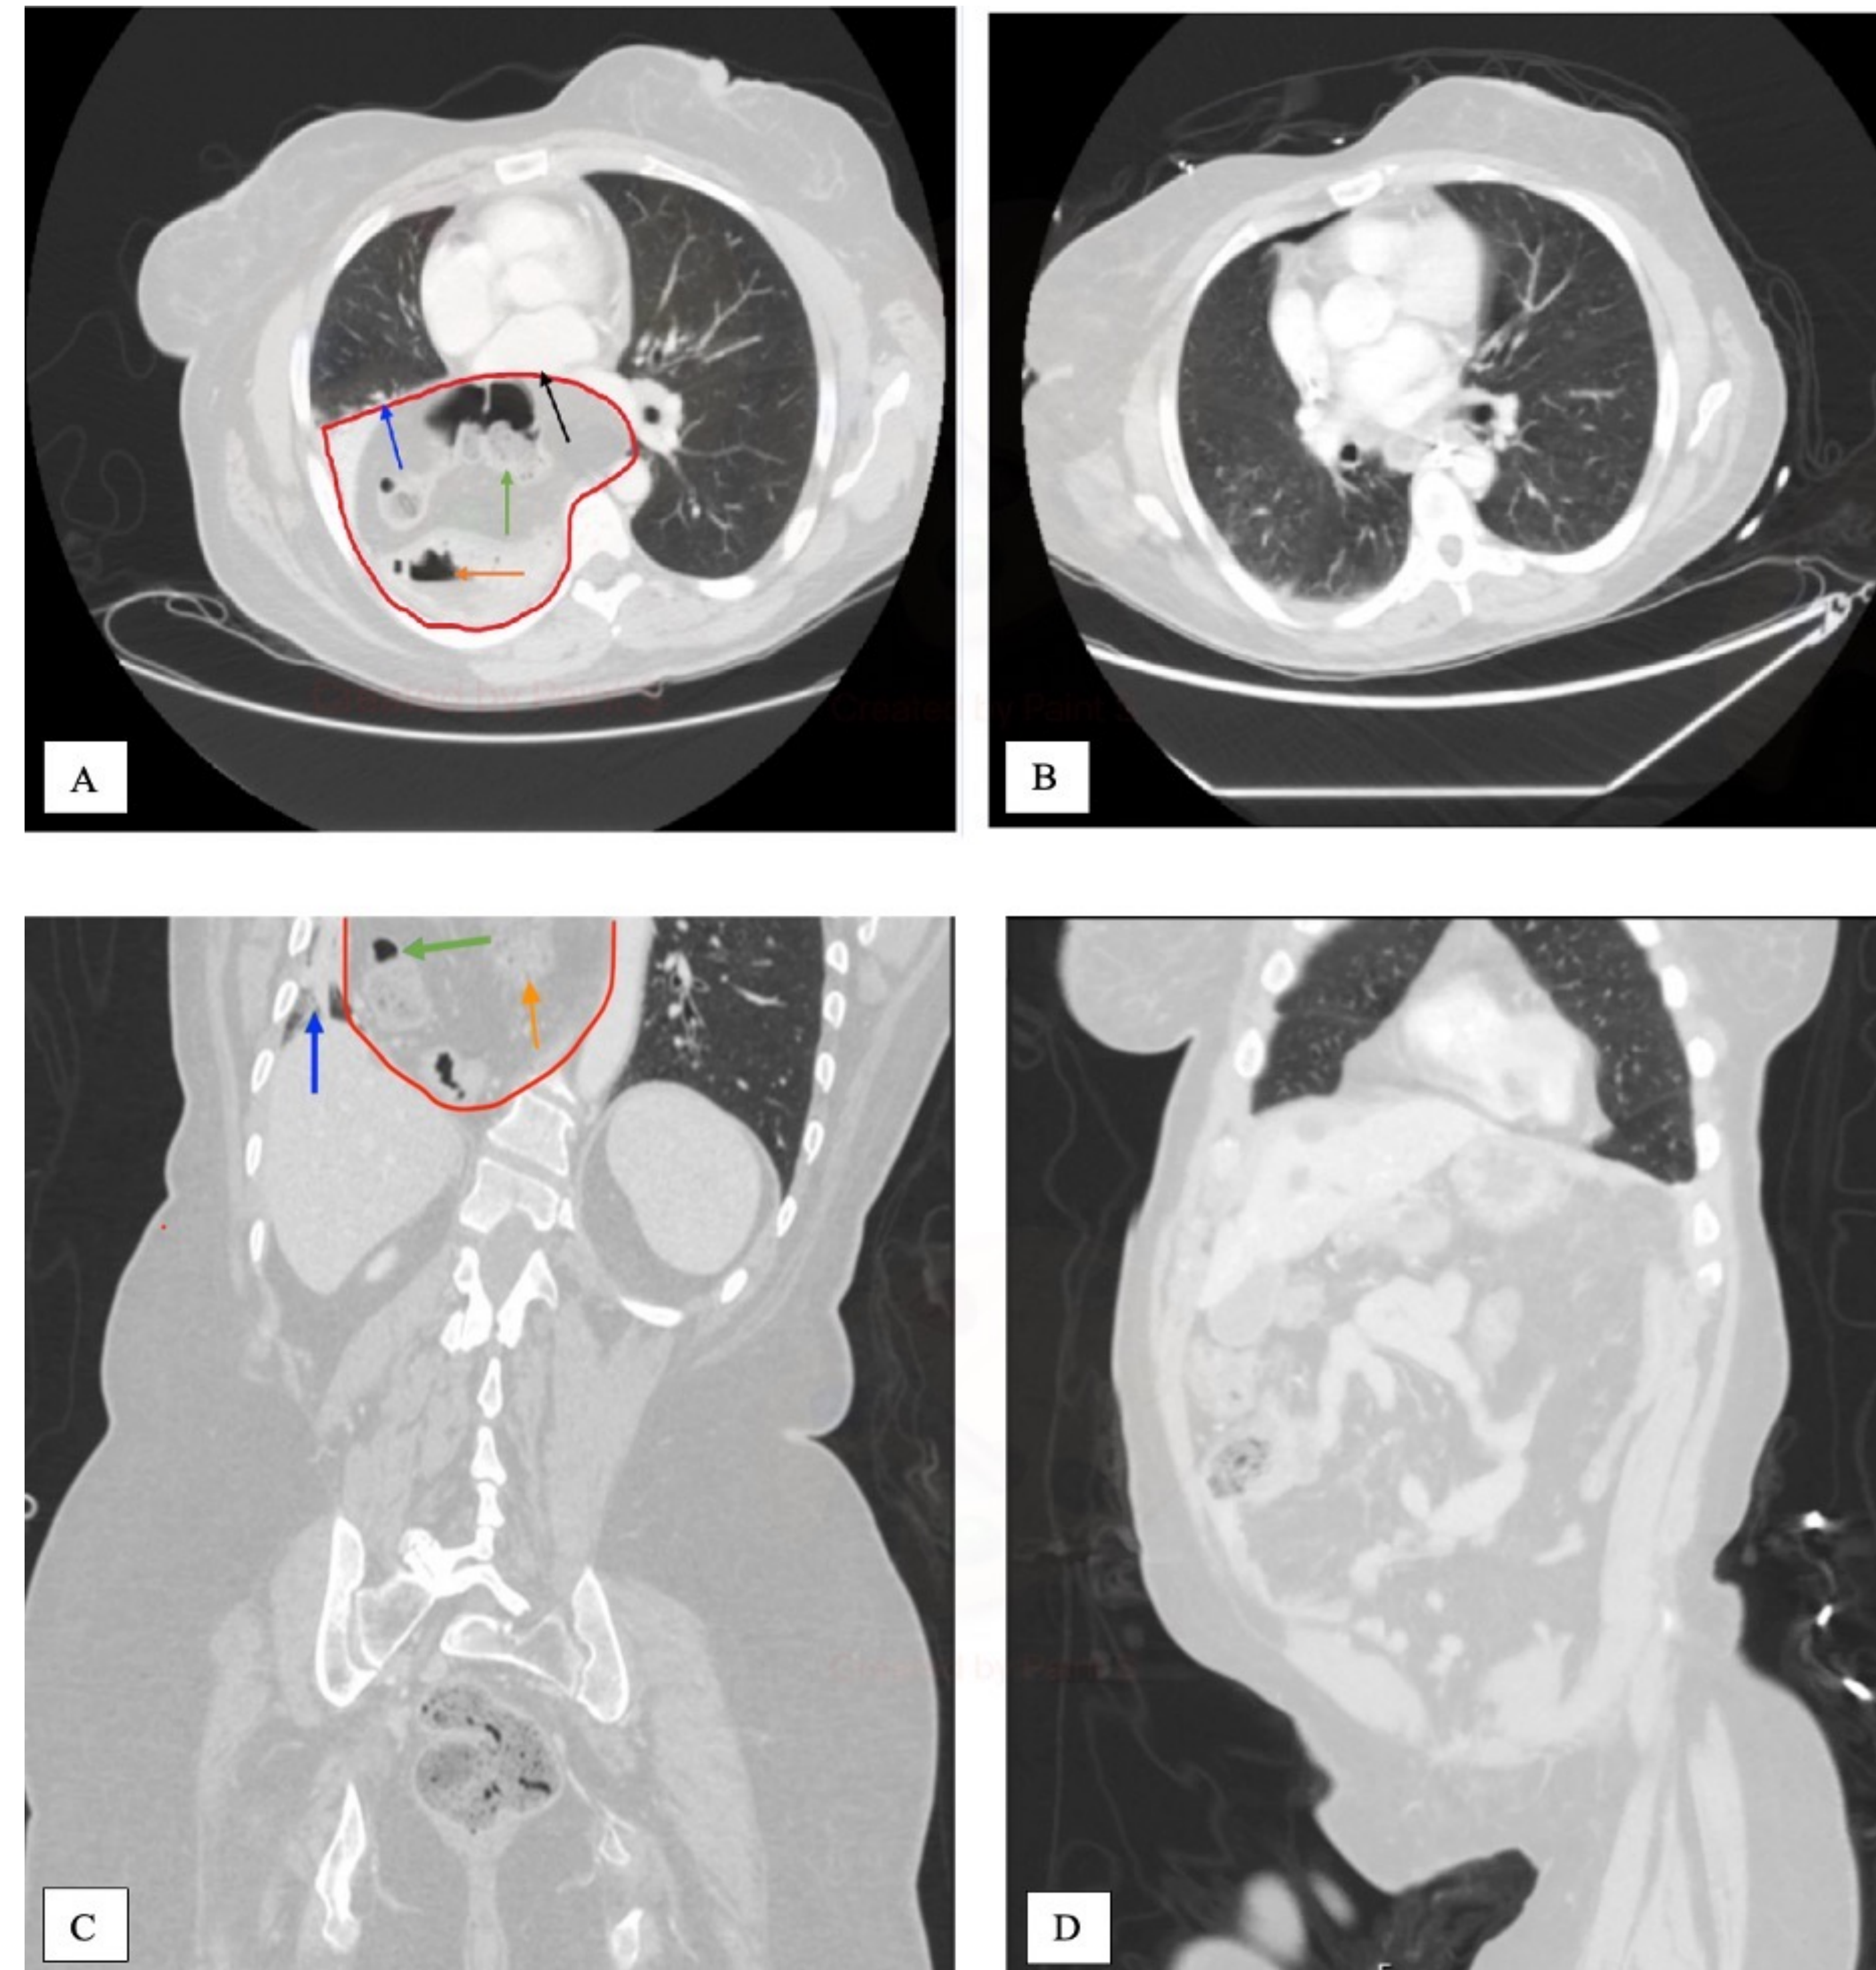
CT Abdomen and Pelvis of Type IV Hiatal Hernia (Red) Compressing Mediastinal Structures
